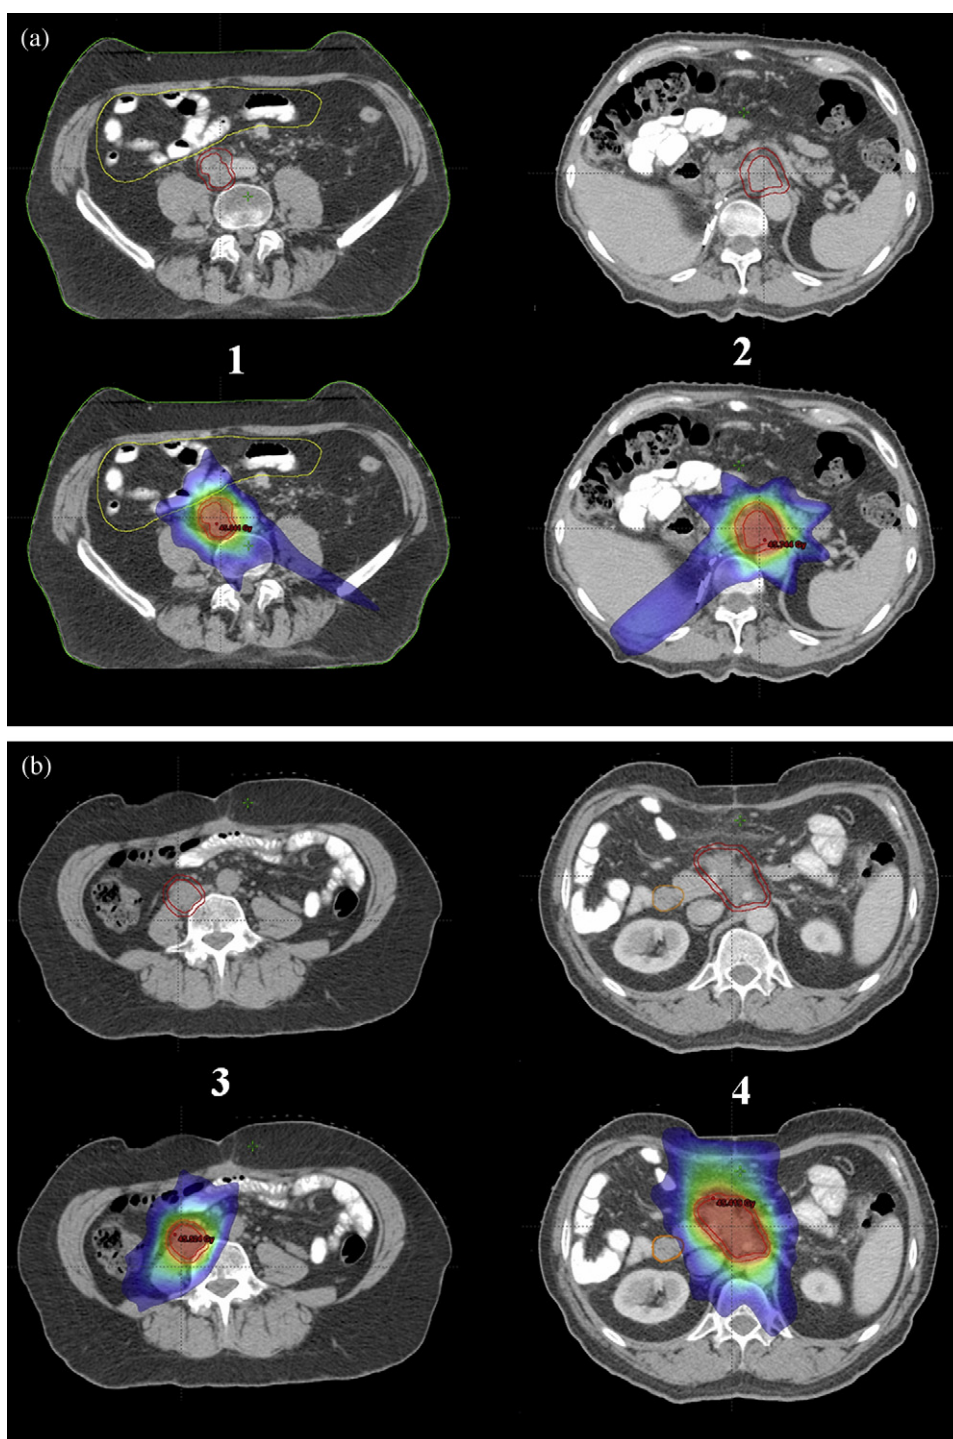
Computed tomography images of four representative cases and their dose distribution displayed in color wash between 15 Gy and 46 Gy (CTV volume: 24.5 cm<sup>3</sup> in Case 1, 20.5 cm<sup>3</sup> in Case 2, 14.8 cm<sup>3</sup> in Case 3, and 49.6 cm<sup>3</sup> in Case 4; planning technique: three-dimensional conformal in Cases 1 and 2 and RapidArc in Cases 3 and 4).
